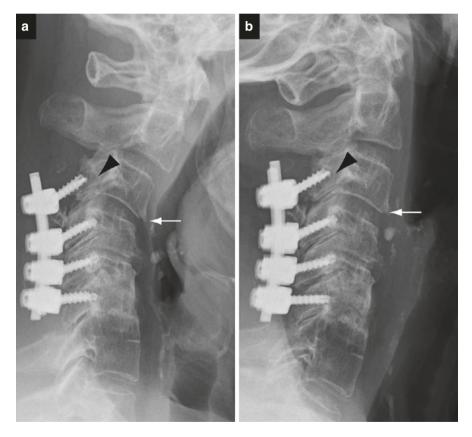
Radiographic evaluation of spinal instability in a patient with prior C3–6 laminectomy and posterior fusion. On the radiograph obtained with the neck in flexion (a), there is 4 mm of anterolisthesis of C3 on C4 (white arrow), which completely reduces on the radiograph with the neck in extension (b). Lucency around the C3 pedicle screws (black arrowhead), which partially pull out of the pedicles on the flexion view, is indicative of screw loosening
